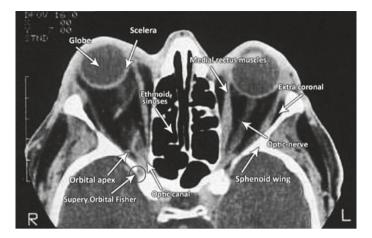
CT-scan in axial view imaged at tissue window setting
